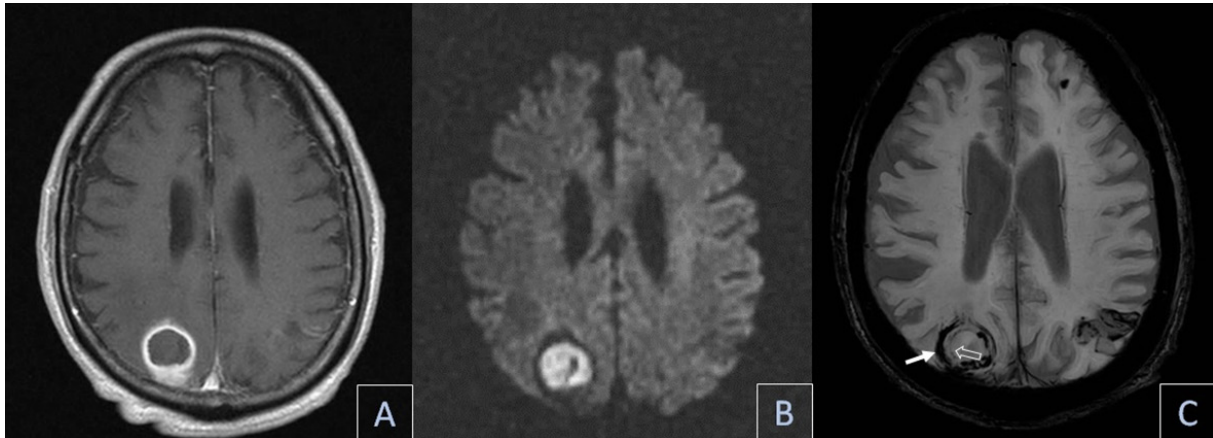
An 80-year-old male was presented with severe AR post bioprosthetic valve replacement with infective endocarditis caused by *Streptococcus gallolyticus* and *Enterococcus faecalis*. Axial MRI post-contrast T1 weighted image (A) reveals smooth rim enhancing abscess in the right parietal lobe with internal restricted diffusion on DWI (B). SWI of the same patient (C) shows a smooth complete outer dark rim (solid arrow) and an immediate internal bright line (open arrow), representing a dual rim sign. Subarachnoid hemorrhage in the left parietal region and a microbleed in the left frontal lobe are also noted.
